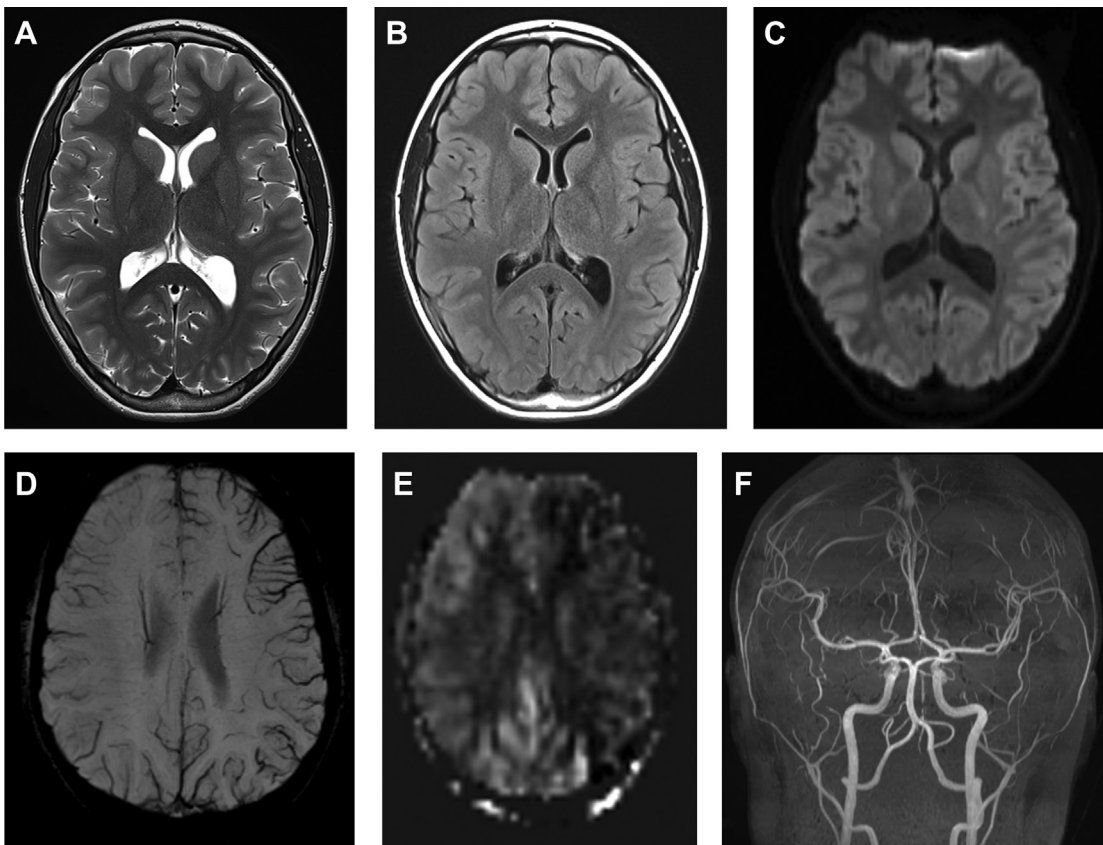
A 14-year-old girl with headache due to hemiplegic migraine, presenting with transient aphasia and right-sided weakness. Axial T2-weighted (A), FLAIR (B), and DWI (C) MR images are normal. Axial SWI (D) demonstrates asymmetric venous prominence in the left cerebral hemisphere, suggesting increased tissue oxygen extraction. ASL (E) shows decreased flow in the left cerebral hemisphere, and coronal maximum intensity projection 3-D reconstruction from time-of-flight MR arteriography (F) shows pruning of distal left middle cerebral artery branches. Imaging abnormalities resolved on 3-week follow-up MR imaging (not pictured).
